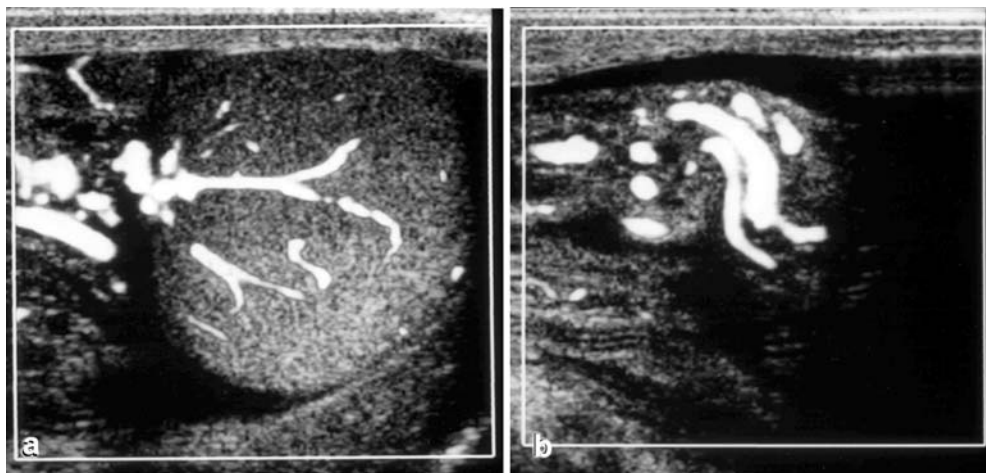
Longitudinal color Doppler US images in a 5.4-year-old boy with 180° right testicular torsion. a Doppler signal of intratesticular vessels is increased. b Note coiled spermatic cord in the inguinal canal just at the entrance to the scrotum. The spermatic cord is swollen
